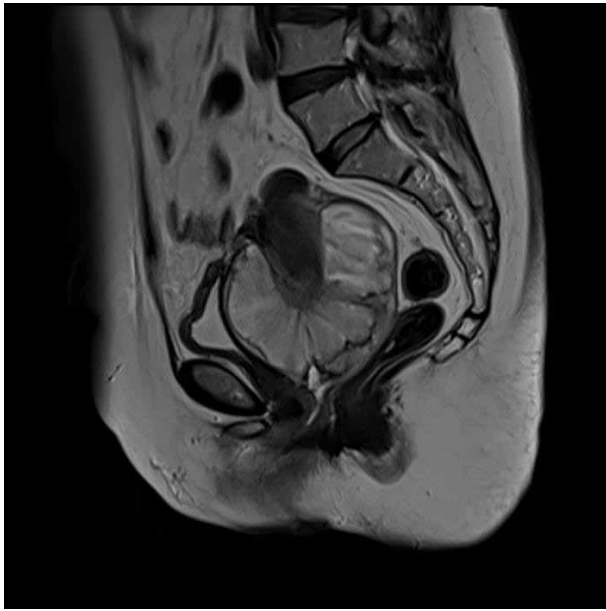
Magnetic resonance imaging (MRI) shows a large mass located in the fundus and protruding towards the vagina.
